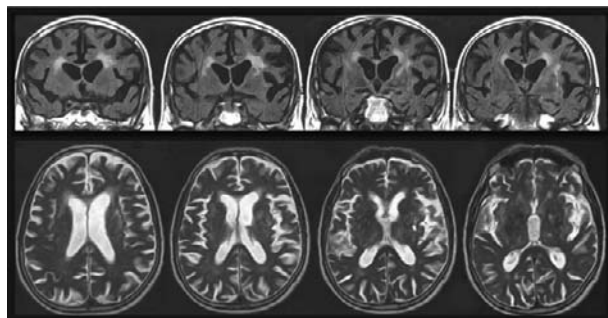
Coronal FLAIR (top row) and axial T2-weighted (bottom row) MRI images showing mild to moderate leukoaraiosis of the frontal periventricular white matter and lacunar infarctions in the left putamen, globus pallidus, pulvinar, and internal and extreme capsules. They are from an 80-year-old right-handed man with a stuttering course leading to progressive nonfluent aphasia.
